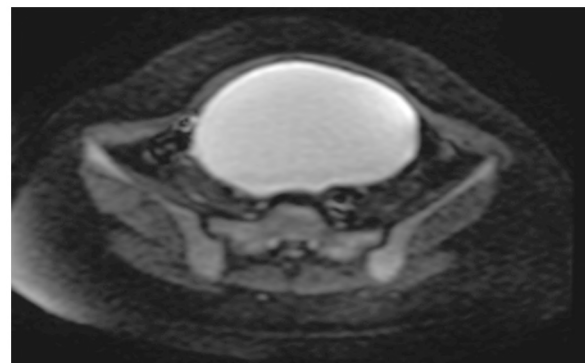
DWI; demonstrates diffusion restriction.
